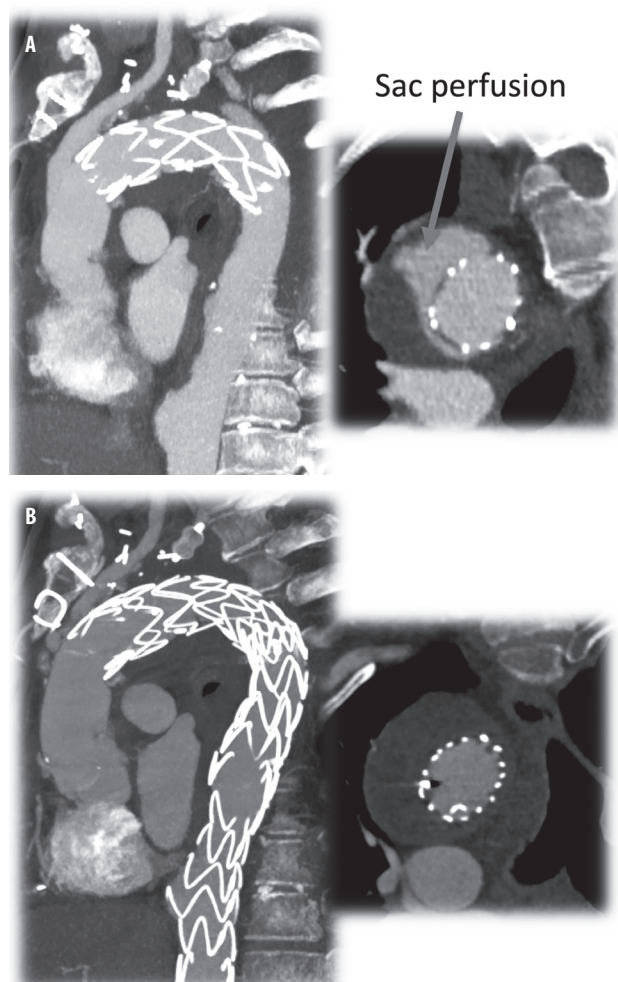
(A) CT scan after frozen elephant trunk procedure with a distal sac reperfusion. (B) CT scan after second-stage thoracic endovascular aortic repair with a complete exclusion of the aneurysm sac.
